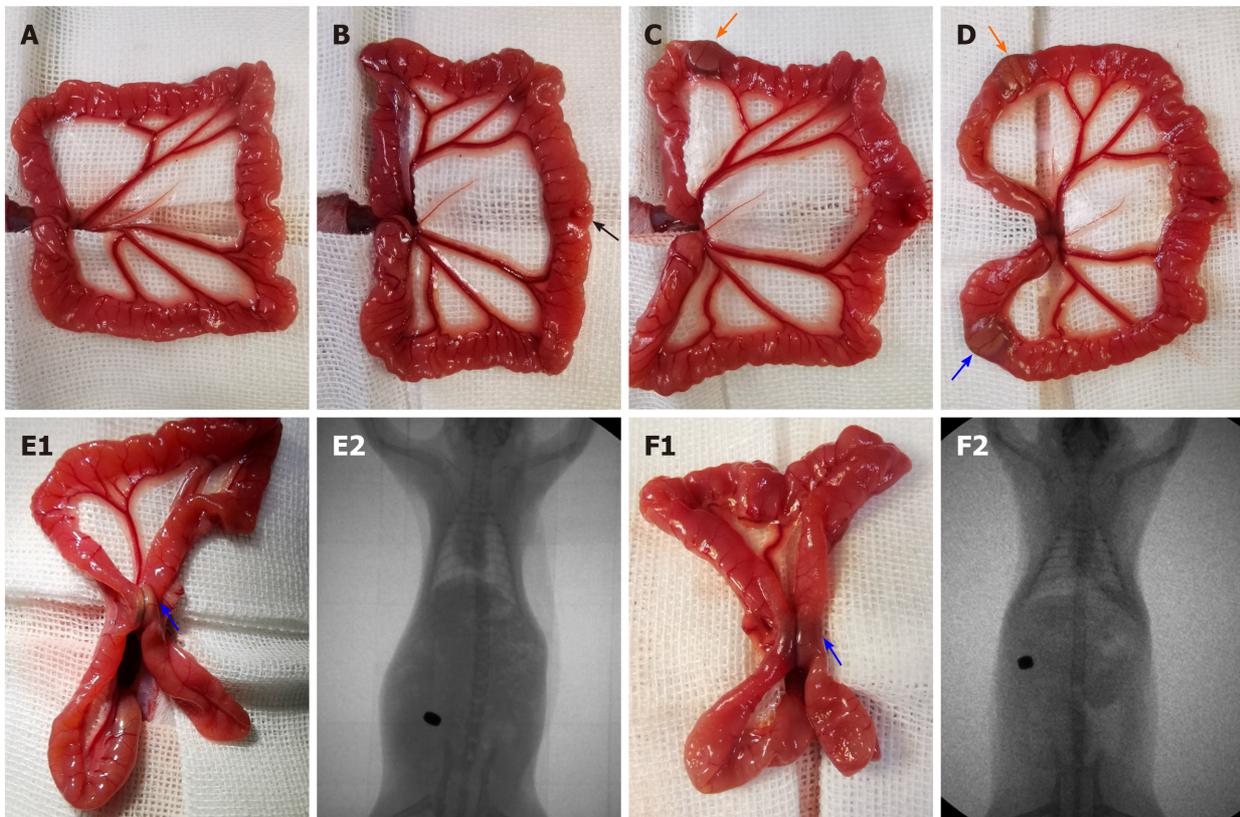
Surgical procedure and X-ray fluoroscopy. A: The small intestine was removed; B: A 6 mm incision was made 12 cm distal to the cecum (black arrow); C: The daughter part (orange arrow) was inserted; D: The parent part (blue arrow) was inserted; E1: Two magnets of the traditional nummular magnetic compression anastomosis (MCA) device were coupled (blue arrow) to compress the ileac wall; E2: Accurate coupling of the daughter and parent magnets in experiment 1 was confirmed using X-ray; F1: Two parts of the fedora-type MCA device were coupled (blue arrow); F2: Accurate coupling of the daughter and parent parts in experiment 2 was confirmed using X-ray.
